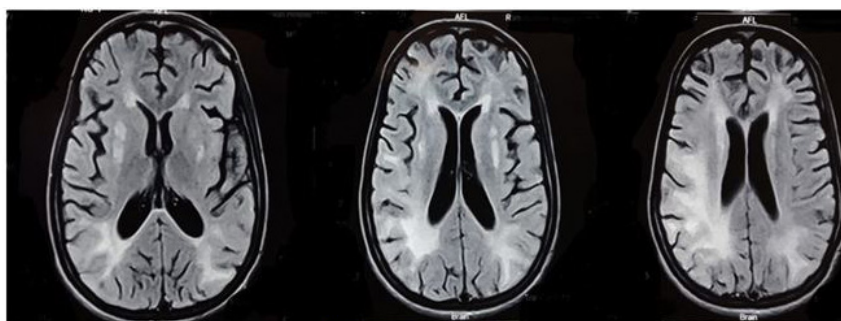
Axial FLAIR images shows bilateral asymmetrical high signal intensity in sub-cortical and deep white matter involving parietal occipital lobes with basal ganglia involvement
